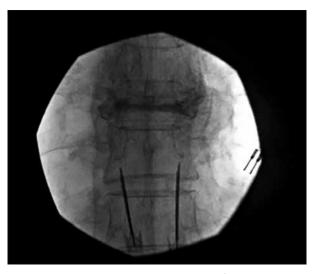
represents a radiographic image of the lead placement for the SPRINT[®] Peripheral Nerve Stimulator device at the level of the T9 spinous processes.
